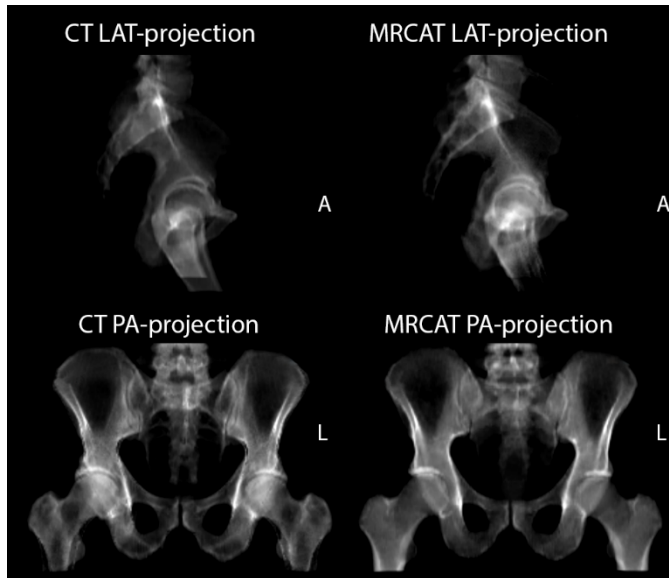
Example of CT (left column) and MRCAT DRR for anterior-posterior (bottom row) and left-right projections calculated in Pinnacle 9.10 treatment planning system (TPS). HU density table is modified to filter out soft tissue contribution.
